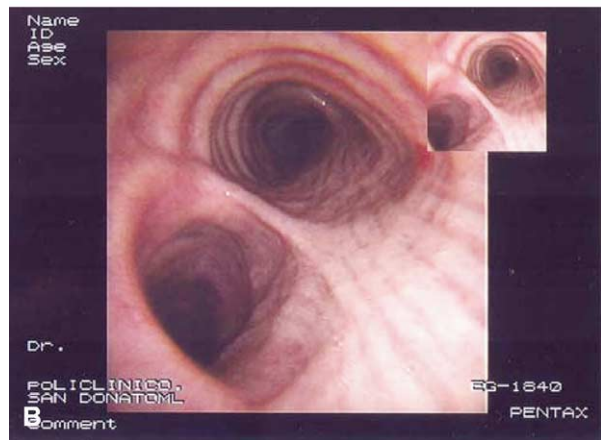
Bronchoesophageal fistula after endovascular repair. A, After successful deployment of a thoracic stent graft, chest computed tomographic scan demonstrates residual communication (arrow) between the left main bronchus and esophagus (arrowhead). B, At 6-month follow-up, complete resolution of bronchoesophageal fistula was documented at bronchoscopy.
